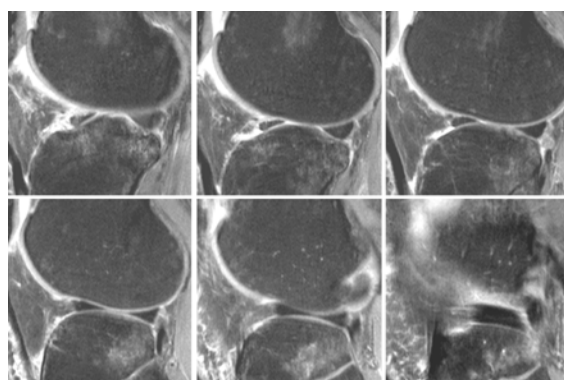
False negative tear. Fat-saturated proton density sagittal MR images (TR/TE;3000/20) from central to peripheral portion, show normal appearing anterior horn of the lateral meniscus. Detachment of anterior horn was detected by arthroscopy, which still cannot be seen even in retrospect. The time interval between MRI and arthroscopy is 36 days. We considered this as unavoidable false negative tear
